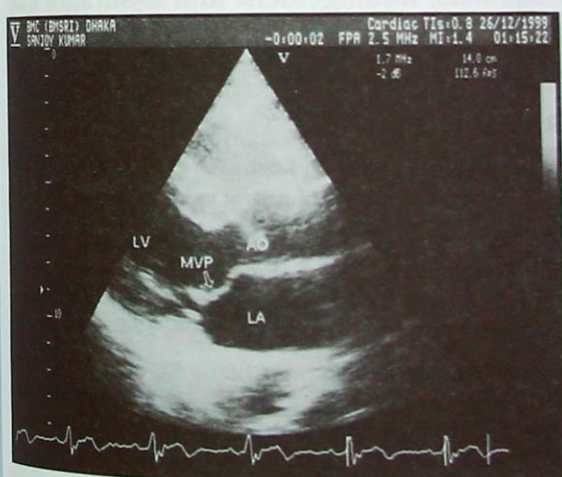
Two-dimensional long-axis echocardiogram of a patient with mitral valve prolapse (MVP). Anterior mitral leaflet (arrow) curves in to the left atrium (LA).
